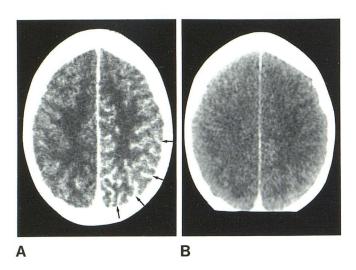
Case 2. A, Enhanced CT scan 1 hr after last focal left hemispheric seizure demonstrates prominent, asymmetric vasculature suggesting hyperperfusion in left hemispheric sulci (*arrows*). B, Enhanced scan 2 weeks later shows return to normal.
